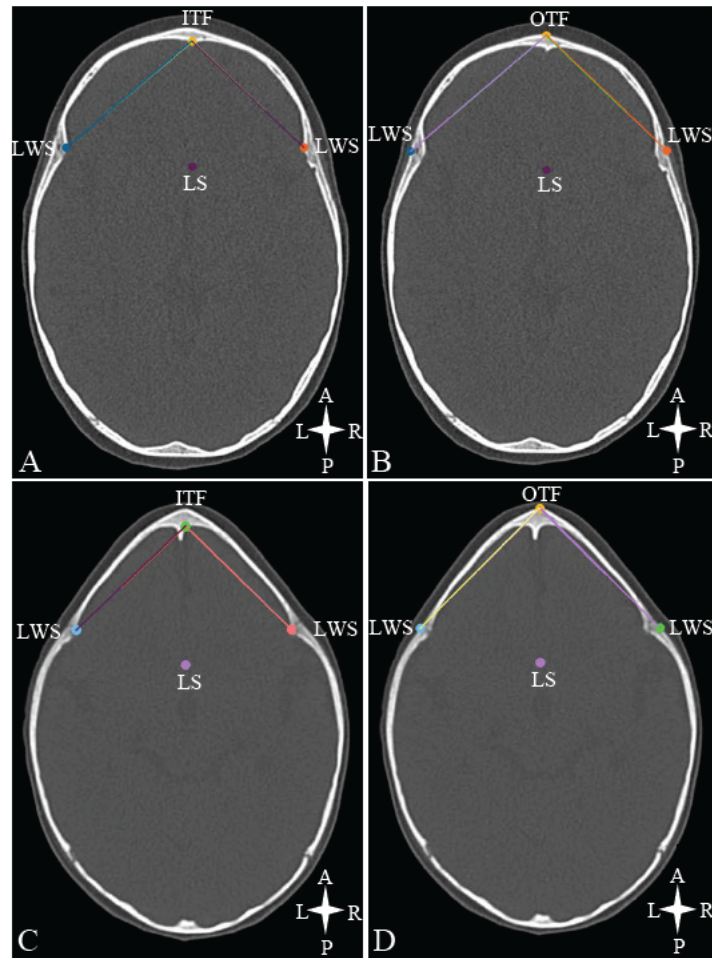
Angles of the ACF on an axial CT scan of a normal patient (A and B) and trigonocephaly patient (C and D) (EBA: vertex at ITF and terminal points at LWS; FA: vertex at OTF and terminal points at LWS). Key: IFT – inner table of frontal bone; OTF – outer table of frontal bone; LWS – lesser wing of sphenoid bone; LS – midpoint of limbus sphenoidale (extrapolated landmark used as a reference plane)
